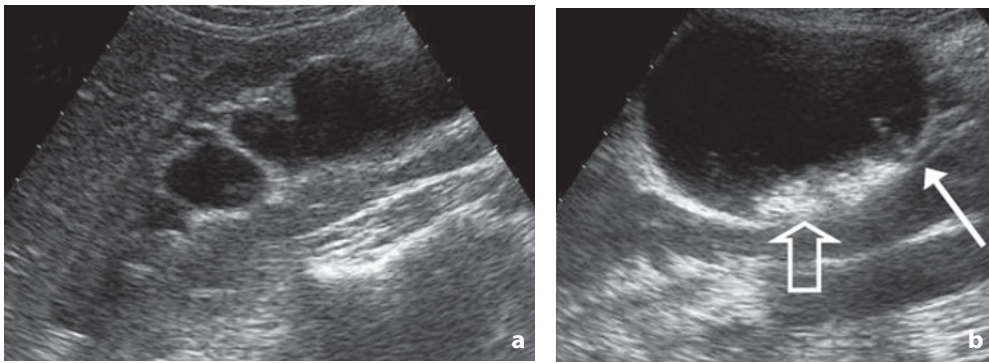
Ultrasonography. Ureteropelvic junction obstruction (patient with right renal colic). US study shows a dilatation of the calices and especially b the pelvis with the ureter of regular diameter immediately distal to the junction (*arrow*). Obstruction is complicated by multiple stones (*open arrow*)
